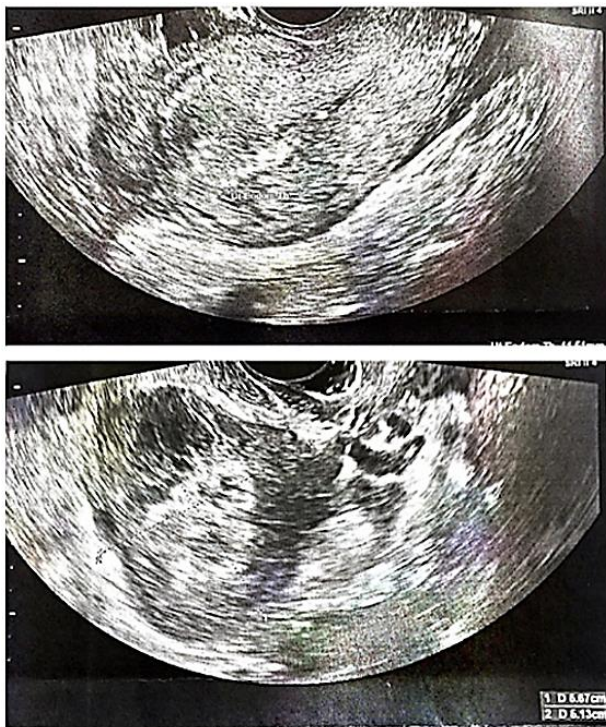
Transvaginal sonography showing ruptured tubal stump ectopic pregnancy.
